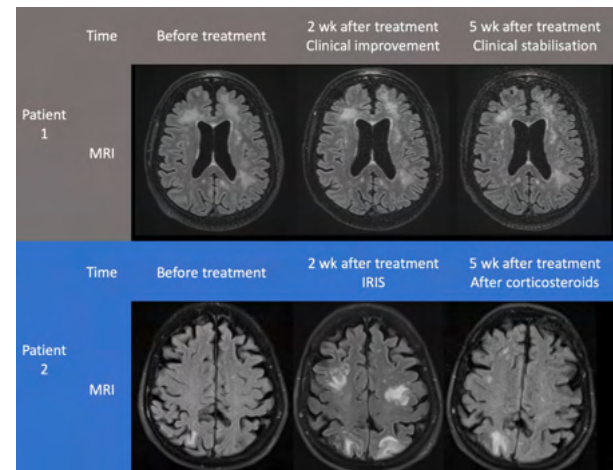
Evolution of cerebral MRI scans (T2-fluid attenuated inversion recovery-weighted imaging) during atezolizumab treatment. Wk denotes weeks.
